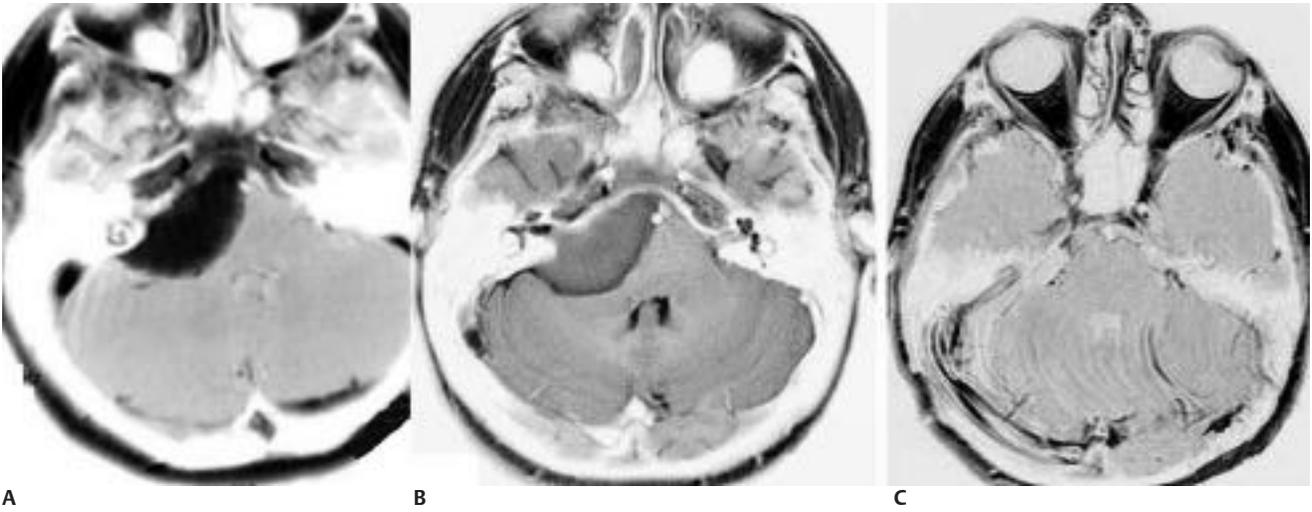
Magnetic resonance imaging (MRI) of a petroclival meningioma that maintains a multiarachnoidal layer, which facilitates intraarachnoidal dissection. (A) Preoperative axial enhanced MRI. (B) Preoperative T2 axial MRI. (C) Postoperative axial MRI demonstrating total removal.
